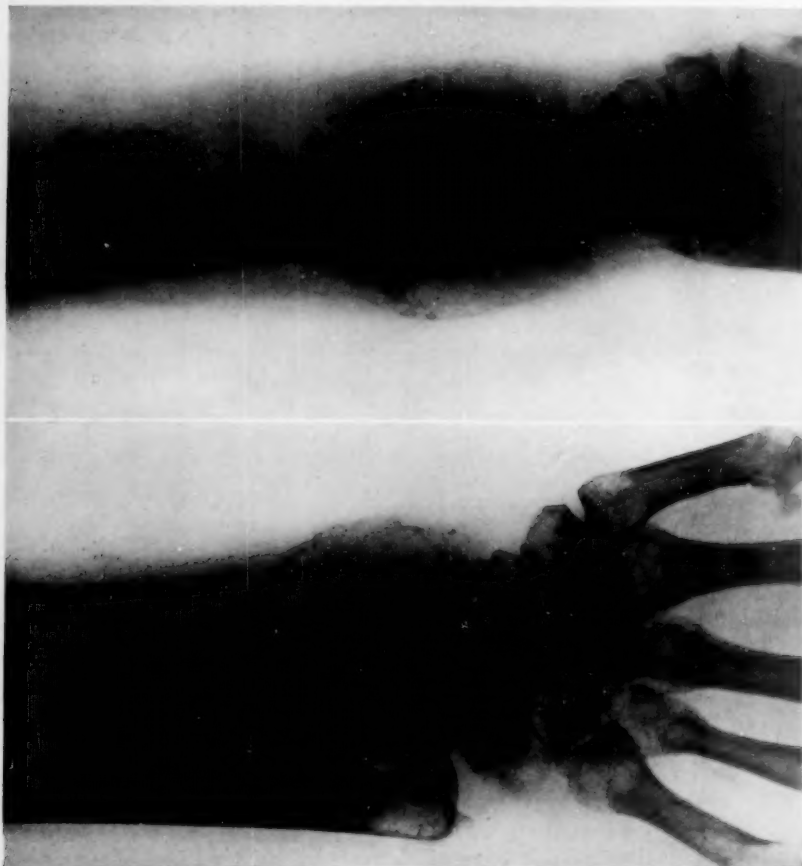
P. N., 37708. X-ray picture of a typical giant-cell tumor in the lower end of the radius, occurring in a white female aged thirty-one. There had been a trauma one year previously, followed by pain. The lesion is too far advanced to show the typical asymmetry but it occupies the epiphysis where it has nearly completely destroyed the bone shell. This lesion recurred after curetting, but was cured by resection and has remained well over two years.
